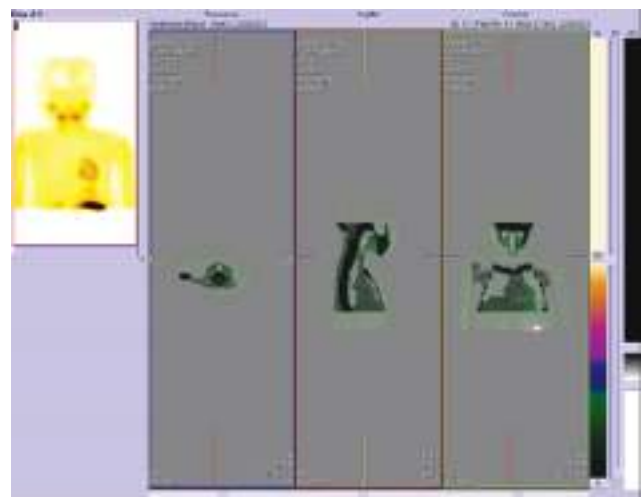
SPECT image of parathyroid scan demonstrated no focal area of increased radiotracer concentration in and around thyroid gland or mediastinal region in transaxial, coronal and sagittal section-which is negative for parathyroid hyperplasia or adenoma.
